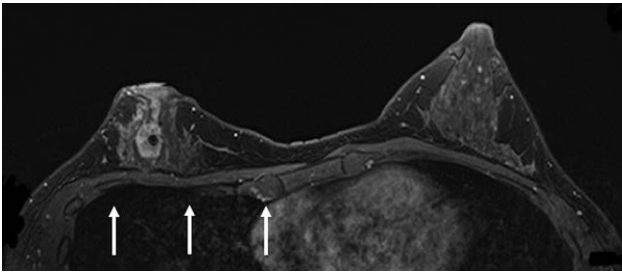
Magnetic resonance imaging of the chest wall of our patient before mastectomy. White arrows show a slight depression deformity in the right chest wall.
